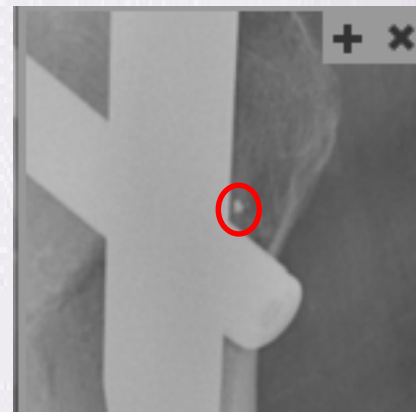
Metallic fragment on X-ray taken on Day 2
